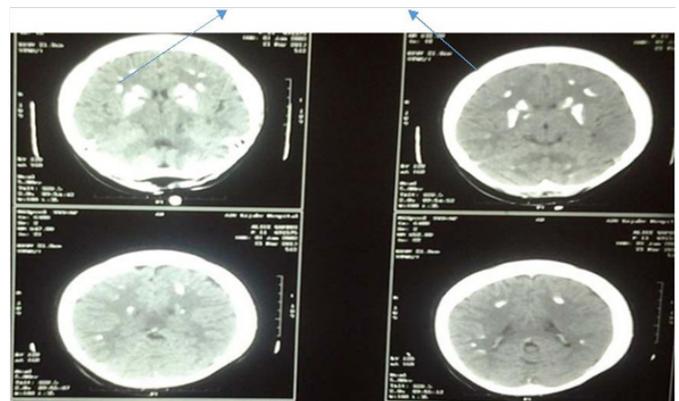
CT-Scan of the brain.
